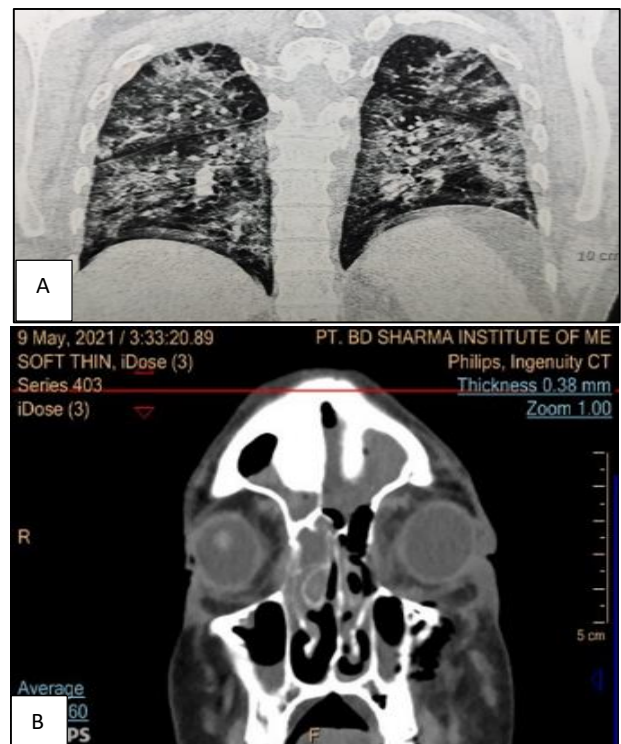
(A and B): Computed tomography (CT) of chest coronal section interlobular and irregular thickening with reticular patterns, multifocal alveolar and consolidative opacities in both lung fields and Coronal section NCCT PNS revealing soft tissue attenuation in B/L maxillary, ethmoid, and frontal sinuses with air locule and extension to medial extra-conal compartments of B/L orbit and left premaxillary space.
